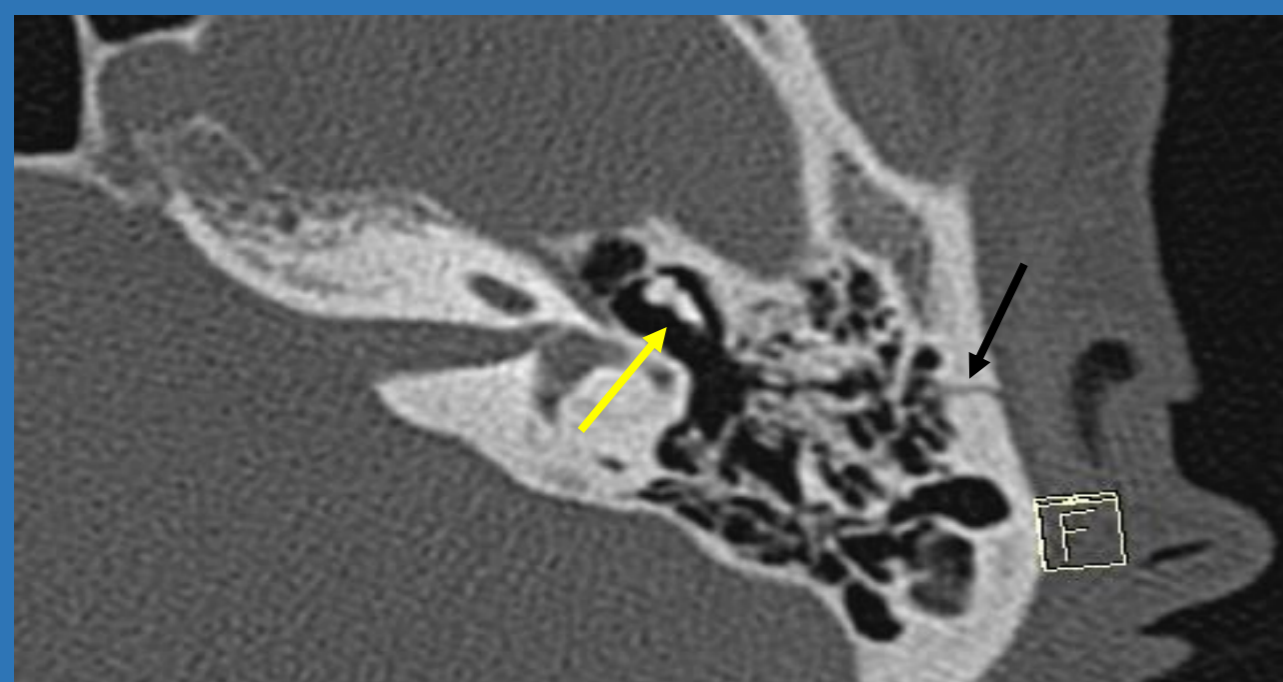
Cone beam computed tomography showing the fracture line of the left temporal bone (black arrow). The yellow arrow displays the incus and malleus, which normally resemble a scoop of ice cream in a cone.
